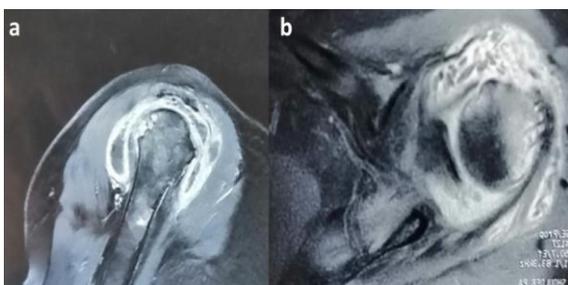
MRI of the right shoulder showing large intra-articular fluid collection with the so-called rice bodies; a: sagittal section, b: axial section
